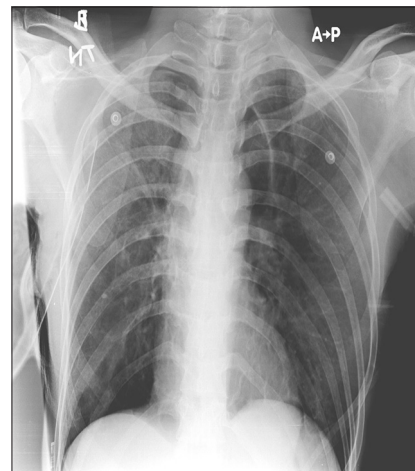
Follow up X-ray chest showing well-expanded lung fields on both sides
